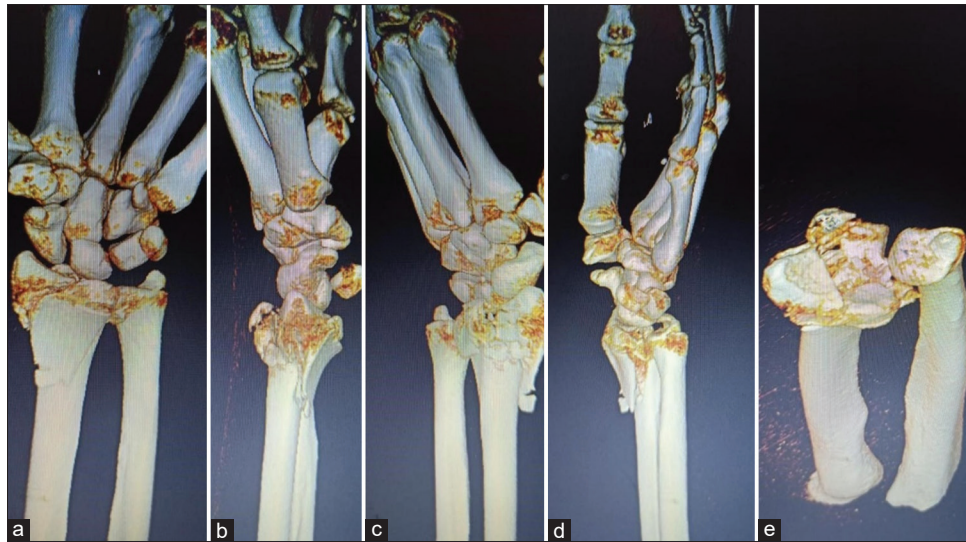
(a-e) Computed tomography showing fracture pattern
